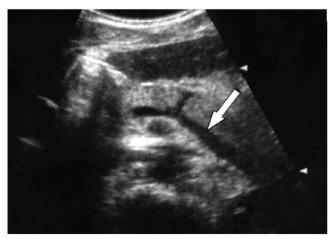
Ultrasound scan (case 2) showing a fracture of the pancreas. The arrow indicates the splenic vein.
